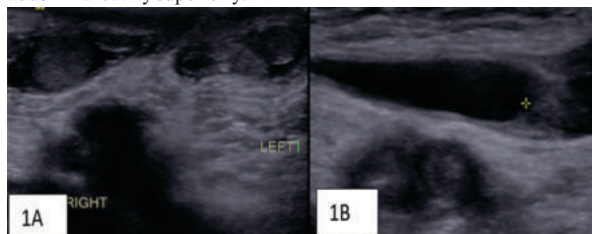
A & B. A- Showing both testes are normal in location & sonographically unremarkable. B: Showing oval shaped cystic lesion along the right spermatic cord, separate from right hemiscrotum.
